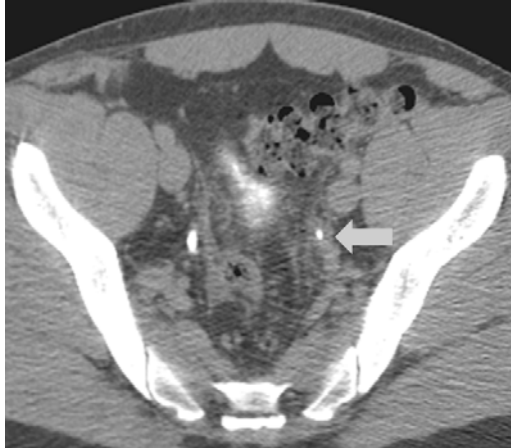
Axial excretory-phase CT urography. Circumferential wall thickening of the left lower ureter was interpreted as urothelial cancer. In the study, a history of a difficult ureteroscopic stone removal was not available at the time of image interpretation.
